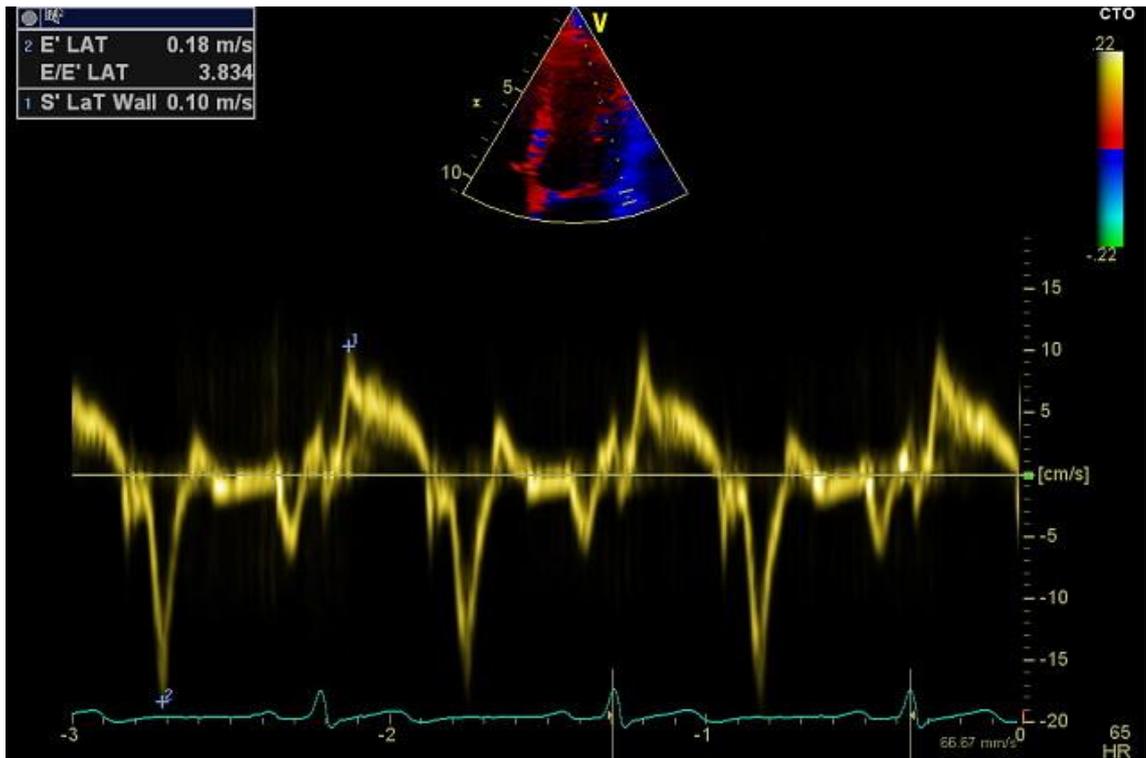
Spectral tissue Doppler: an example of normal systolic velocity in the lateral wall
